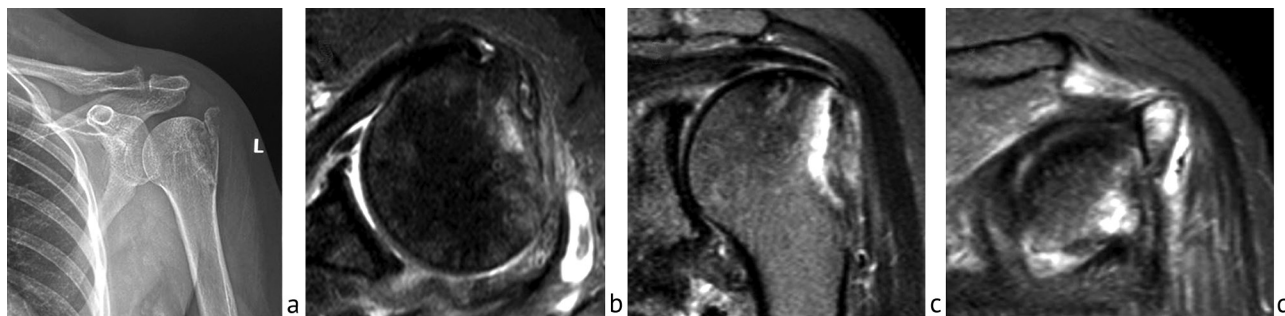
(a) anteroposterior view of the shoulder joint at 3 months of a traumatic shoulder dislocation; (b) axial T2 MRI of the shoulder joint with fat suppression demonstrating the absence of the greater tubercle of the humerus; (c) coronal T2 MRI of the shoulder joint with fat suppression showing the absence of the greater tubercle and the loose-lying supraspinatus tendon; (d) coronal T2 MRI of the shoulder joint with fat suppression showing the greater tubercle remnants dislocated into the subacromial space with signs of avascular necrosis
